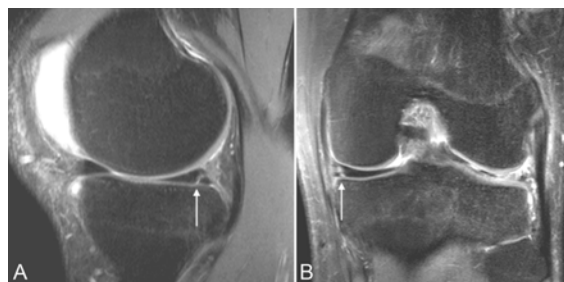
False positive tear. Fat-saturated proton density sagittal (A) and coronal (B) MR images (TR/TE; 3000/20) show findings consistent with medial meniscal tear at peripheral third of posterior horn (arrows). Arthroscopy result is “fraying” of posterior horn. The time interval between MRI and arthroscopy is 55 days in this case. Communitated tear of the lateral meniscus is observed
